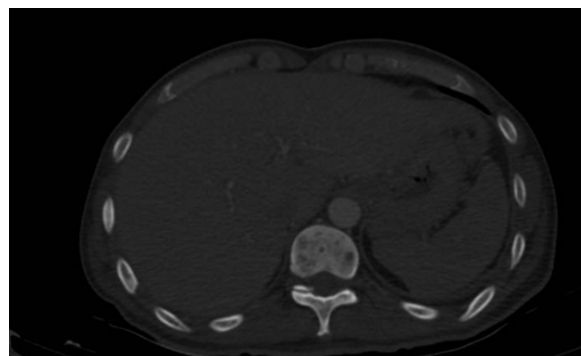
Hepatomegaly and osteolytic bone lesions on CT scan
